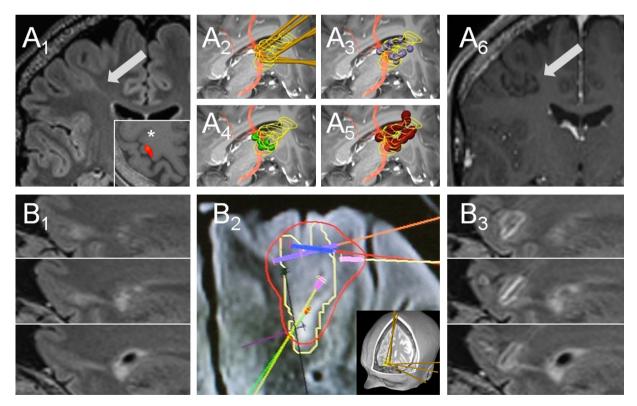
(A1) 3 Tesla MRI (1 mm \times 1 mm \times 1 mm FLAIR) clearly indicates the existence of a FCD type IIB of Palmini and Lüders (arrow) with a funnel-like signal extension from a thickened cortex to the ventricle wall. Insert A1: the lesion (*) is located close to the hand-representation of the precentral gyrus according to functional magnetic resonance imaging. (A2) In patient A, six trajectories where chosen to impale the lesion (yellow outline), which is located close to the pyramidal tract according to diffusion weighted imaging-based fibre tracking (light red). (A3–5) Blue spheres indicate the sites within the lesion at which a bipolar EEG was recorded via the RFTC device; green spheres indicate the sites of stimulation for motor evoked potentials; and red spheres indicate the final coagulation sites. (A6) MRI of patient A one year after RFTC documents the extinction of the previous lesion. (B1) Also in patient B, the high resolution 3D-FLAIR indicates a FCD IIB with trans mantle sign towards the ventricle. (B2) In patient B, seven trajectories were chosen to allow coagulation of the lesion (screenshot of the coagulation plan). (B3) The 3D-FLAIR of patient B two months after intervention indicates only a minimal amount of oedema around the coagulation sites, which is equivalent to the amount of oedema patient A showed at 3 months post-op (not shown).
